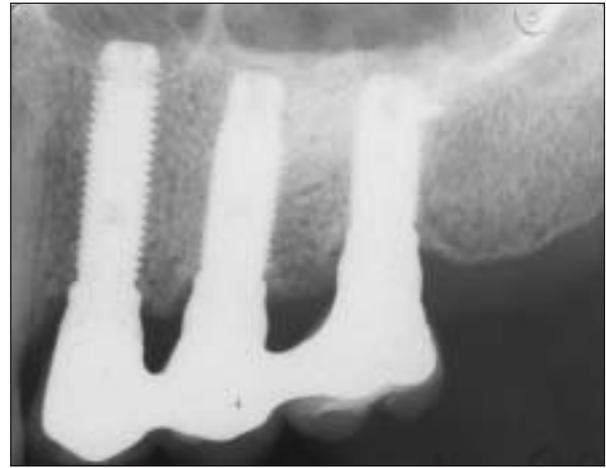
Two-year postoperative radiograph.
